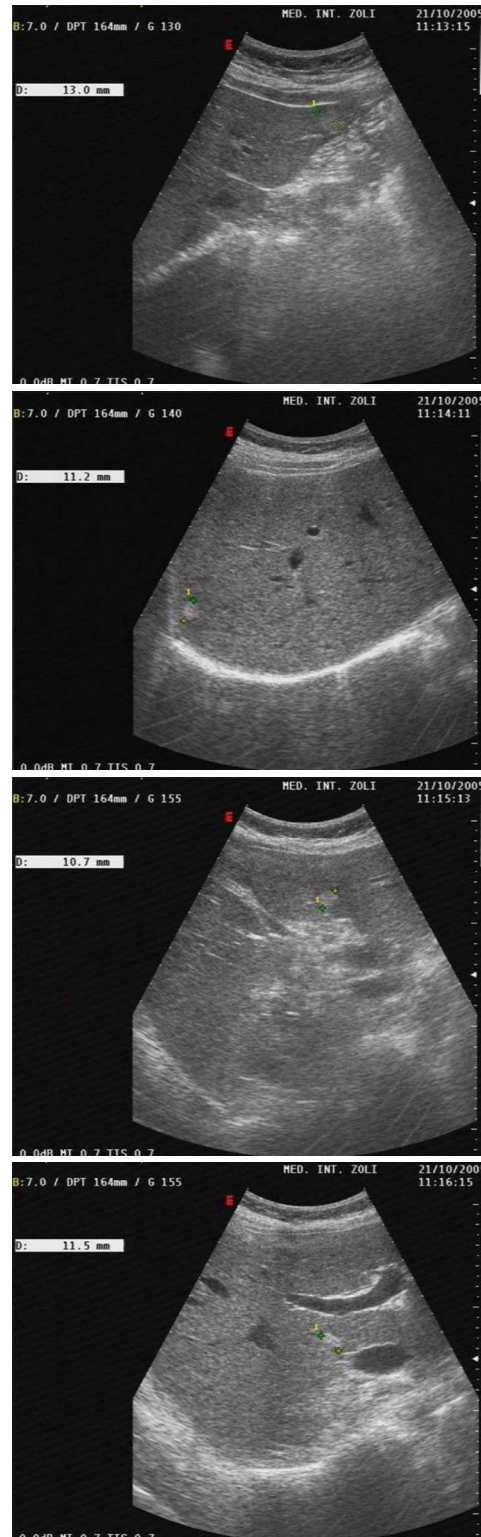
Ultrasonographic appearance of multiple hemangiomas in one of the studied patients. In this 47-year-old woman, 4 hepatic lesions were detected in 4 different segments of the liver.
